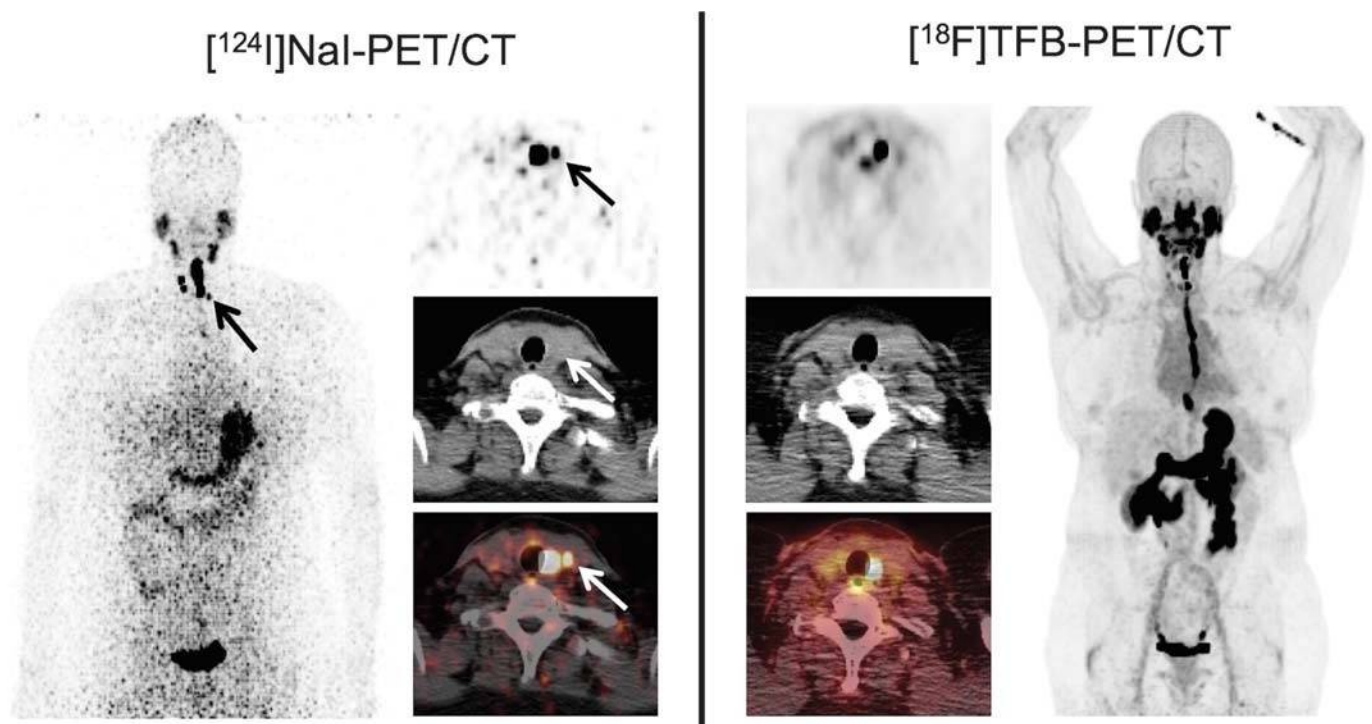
Comparison local thyroid remnant detection by [¹⁸F]TFB- and [¹²⁴I]NaI-PET/CT. Display of maximum intensity projections (MIP; outer columns) and transaxial PET and combined PET/CT slices (inner columns). The 56-year-old patient (patient 1) with PTC presented after total thyroidectomy (pT1b). [¹²⁴I]NaI- and [¹⁸F]TFB-PET/CT revealed remnant benign thyroid tissue in the thyroid bed and along the thyroglossal duct with 2 foci of remnant tissue missed by [¹⁸F]TFB (arrows). No lesions suspicious for malignancy were detected.
